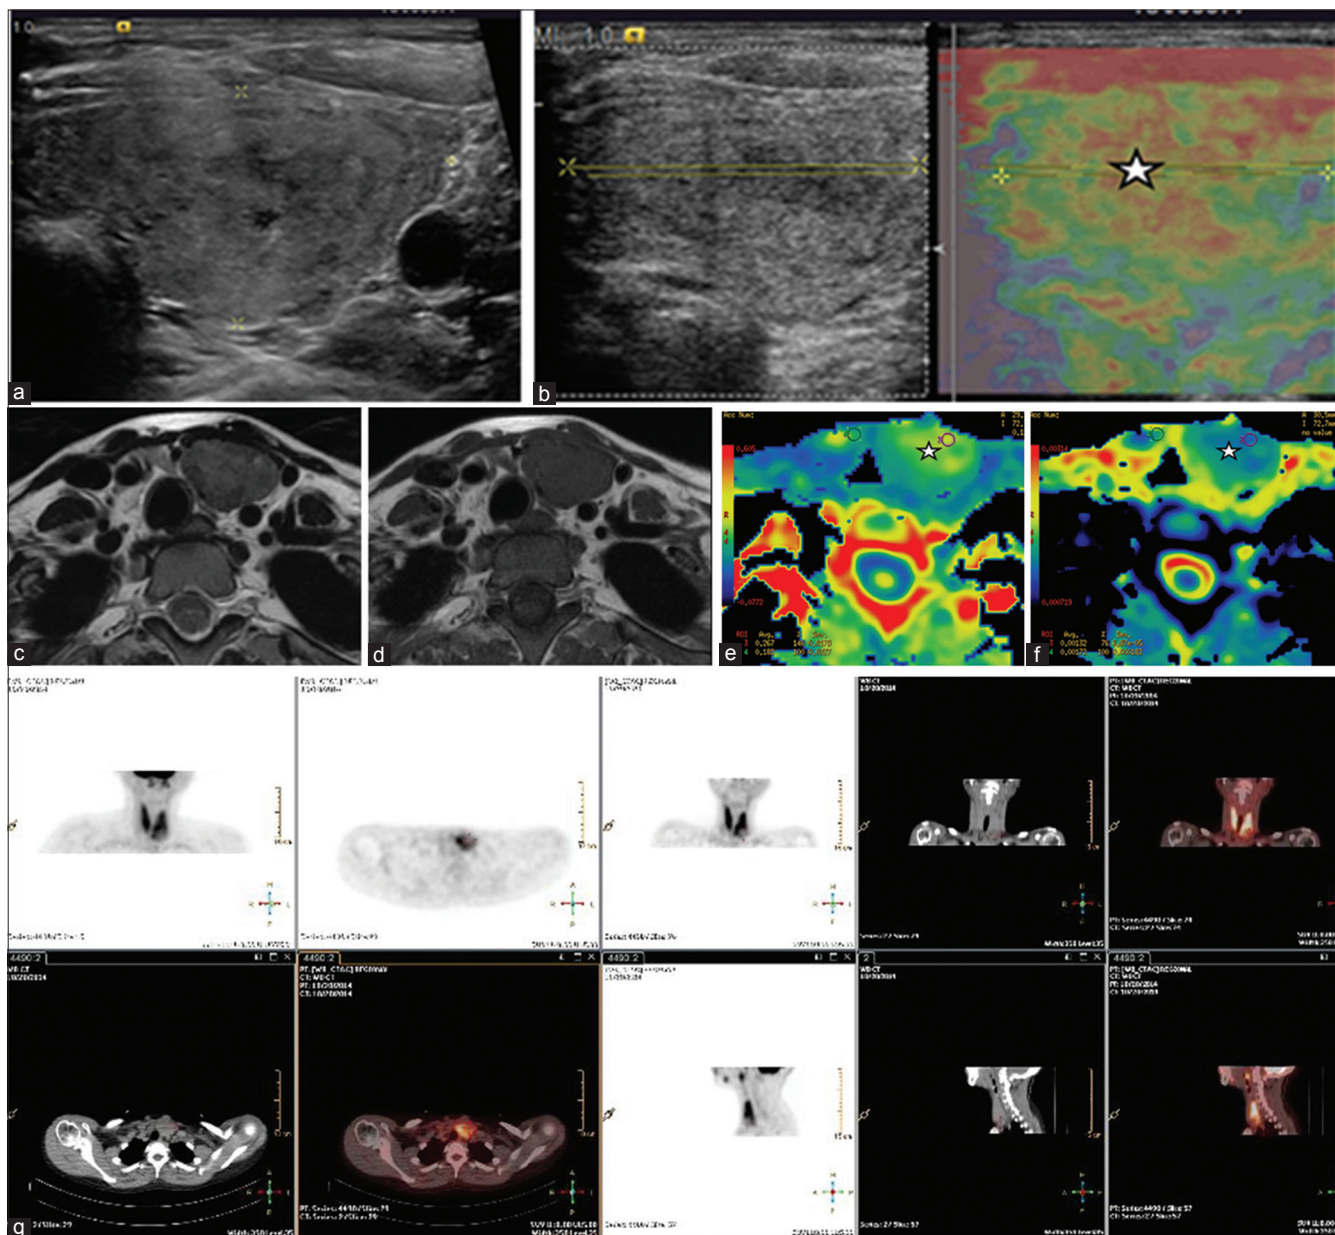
(a) Grey scale transverse ultrasound showing a heterogeneous predominantly iso to hypoechoic lesion ($3.7 \times 1.9 \text{ cm}$) that was cold on $^{99\text{m}}\text{TcO}_4$ scintigraphy. (b) Split-screen B-mode ultrasound image (left) and US elastogram (right) showing a predominant stiff nodule (star). The Rago and Asteria Strain elastographic scores of the lesion were 3 and 3 respectively. (c and d) Plain MRI showing a predominantly iso to hypointense on both T2W images and T1W images respectively. (e and f). Diffusion colored maps of EADC and ADC value obtained from ADC map with b factor 0 and 500. The ADC map of the left side nodule (star) showed diffusion pattern similar to the normal parenchyma the right lobe of thyroid with a measured ADC value of $1.82 \times 10^{-3} \text{ mm}^2/\text{s}$ which represented area of stiffness on elastogram. (g) FDG-PET/CT demonstrating a predominantly to be FDG non-avid nodule in a background of diffuse uptake indicating associated thyroiditis like picture in the rest of the thyroid gland
